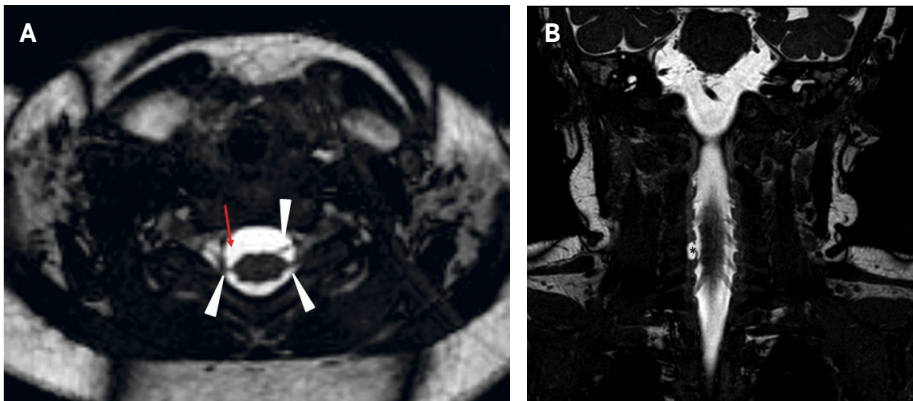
a and b MRI images showing injury to the brachial plexus
